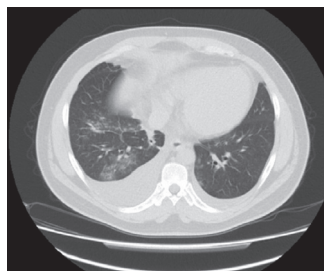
Control Thoracic CT showing bilateral pleurisy (slightly decreased on the left and similar appearance on the right), acinar densities and slightly decreased but persisted consolidations in the parenchyma.
